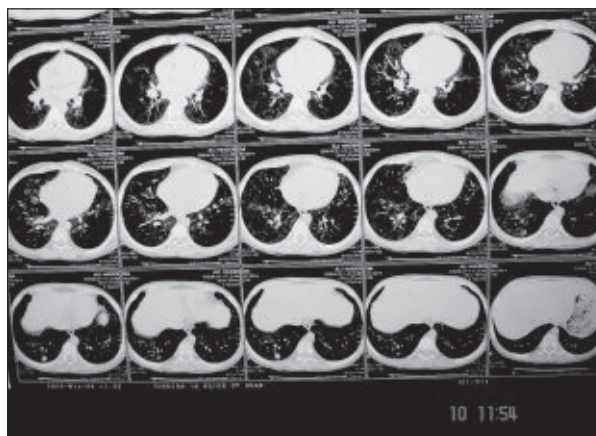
HRCT of chest in multiple sections showing bilateral reticulonodular shadow.
